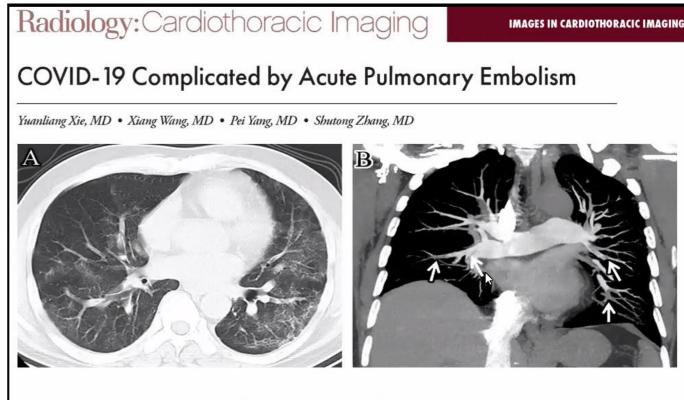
Images in a 57-year-old man with COVID-19 pneumonia. A, Axial unenhanced chest CT scan obtained on day 10 after the onset of symptoms
